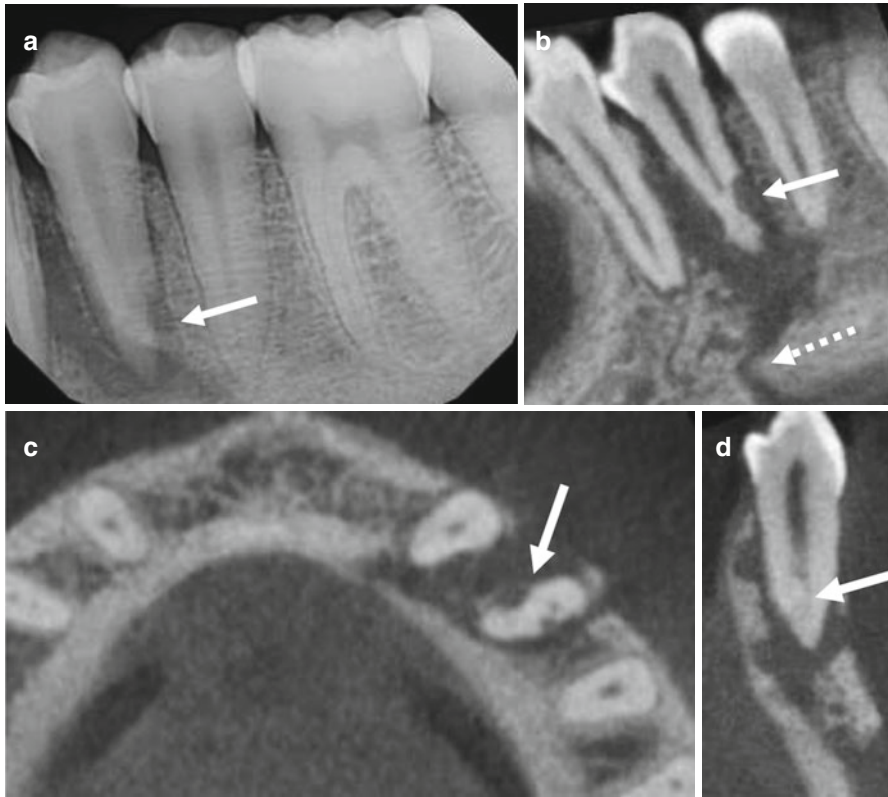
A 21-year-old male presented for evaluation and possible treatment with a history of trauma to the mandibular left quadrant. The left mandibular body fracture was directly fixated for 6 weeks prior to endodontic evaluation. (a) Periapical image shows an area of low density associated with the mandibular left first premolar. This feature extends laterally and apically. There is a well-defined area of low density on the distal aspect of the apical third of the root (*arrow*); a feature consistent with external inflammatory resorption. CBCT images of the (b) sagittal reformation demonstrates the full extent of the lesion, which is contiguous with the fracture line (*dashed arrow*). (c) A separate area of low density (*arrow*) shows on the mesial aspect in the axial reformation. (d) There is an apical split of the canals visible in the cross-sectional reformation
